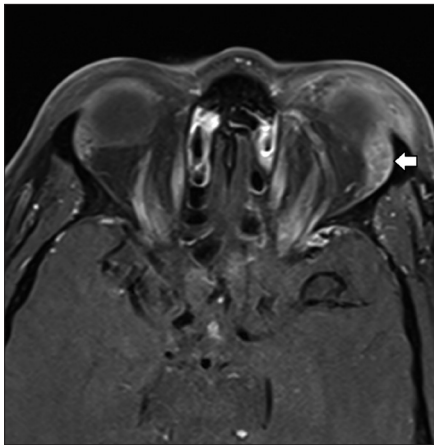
Axial T1-weighted contrast-enhanced MRI of the orbits showing asymmetric thickening and enhancement of the left lacrimal gland (*left arrow*). Incisional biopsy showed IgG4-related sclerosing dacryadenitis.
